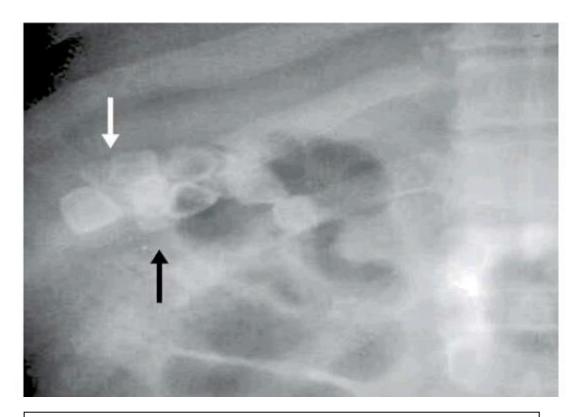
multiple gall stones in plain xray abdomen showing radio opaque shadow
